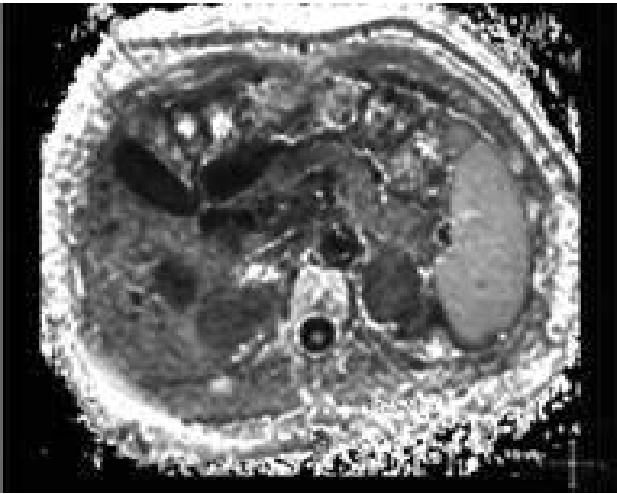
MRI of 55-year-old woman with metastatic breast cancer. The solitary metastatic lesion of segment 6 demonstrates restricted diffusion: It is hyperintense on T2 WI (a) and remains hyperintense on DW MRI at $b = -1000 \text{ s/mm}^2$ (b) with low ADC 0.85 s/mm^2 (c).
